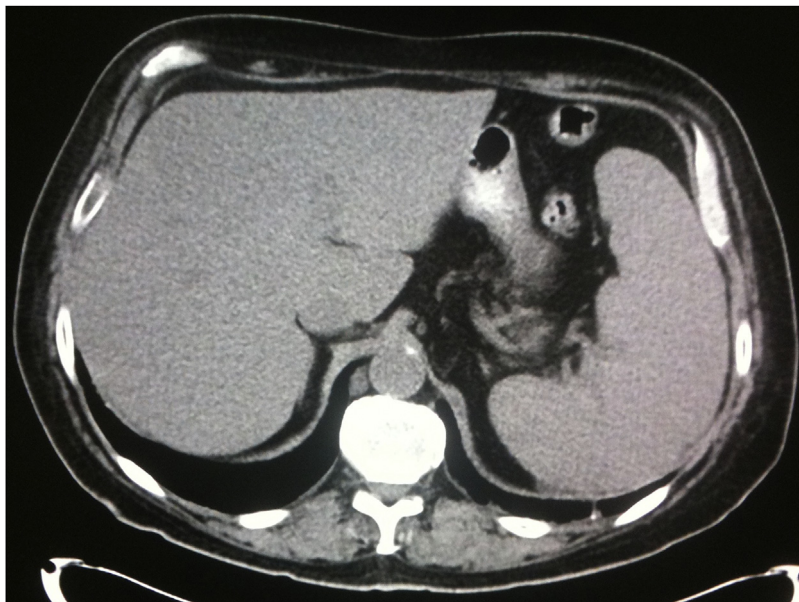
{[[Fig. 3]]} CT abdomen: splenomegaly.
